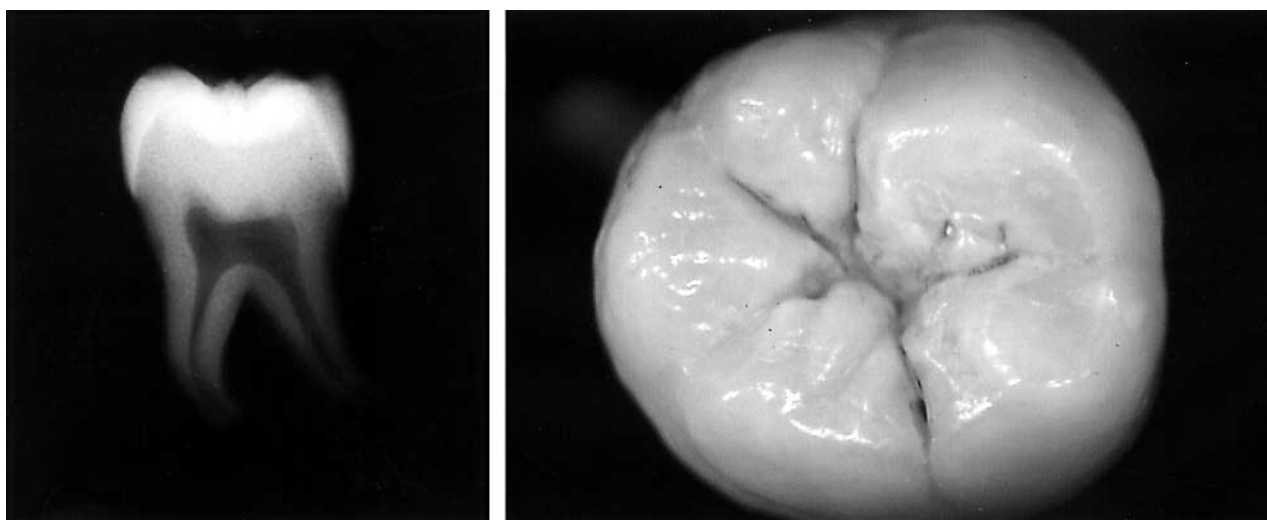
Tooth B – clinical and radiographic appearance of a second molar.
